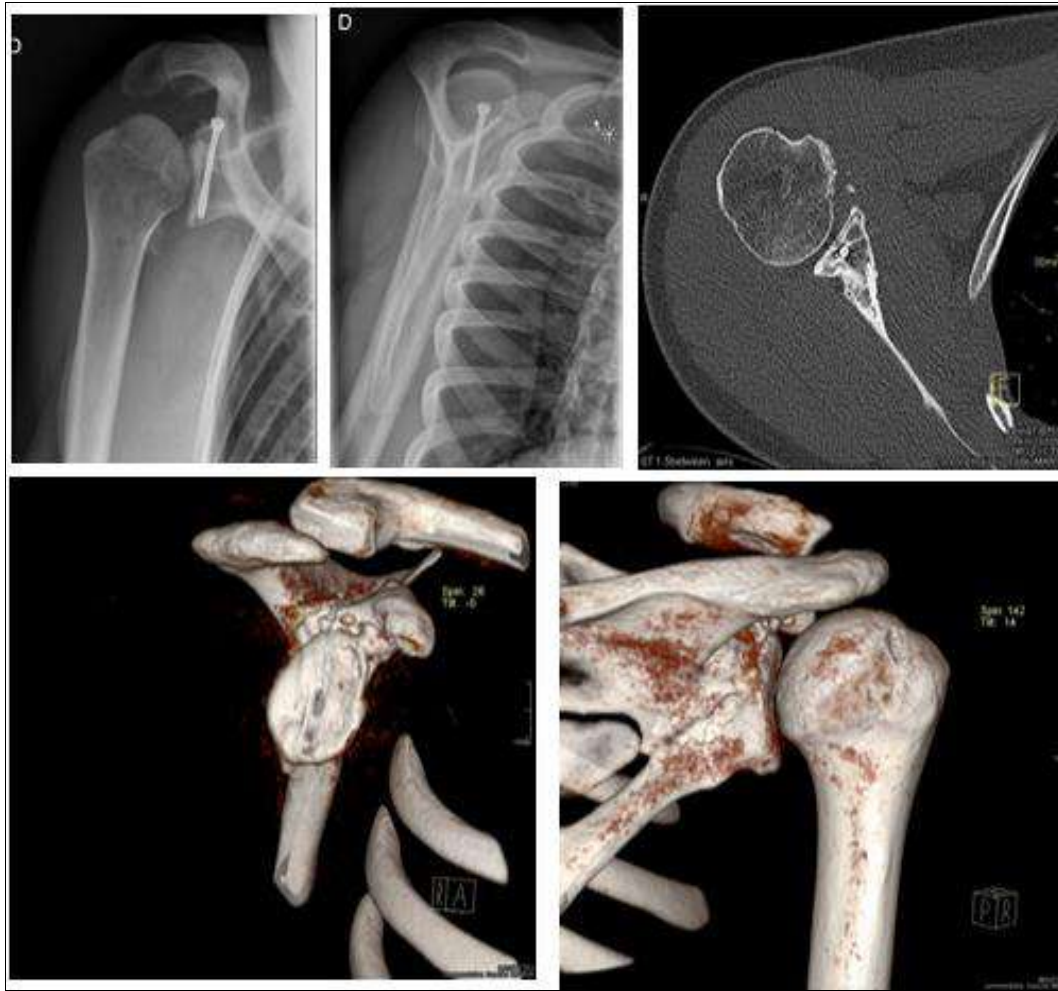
16 weeks after surgery: AP and lateral radiographs and CT scan.
